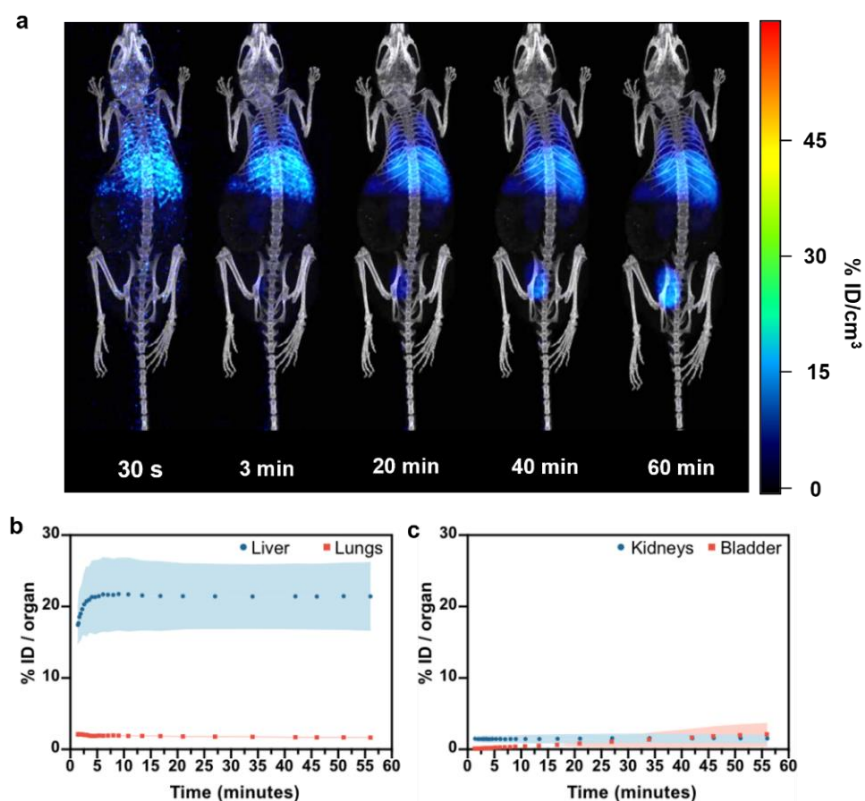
Biodistribution of ^{18}F -urease nanomotors after intravenous administration. a) PET-CT coronal images (maximum intensity projections) obtained at different time points. Time-activity curves of ^{18}F -urease nanomotors in the liver and lungs (b) and kidneys and bladder (c), as determined by PET imaging. Results are expressed as percentage of injected dose per organ (mean \pm SD, $N = 2$).
